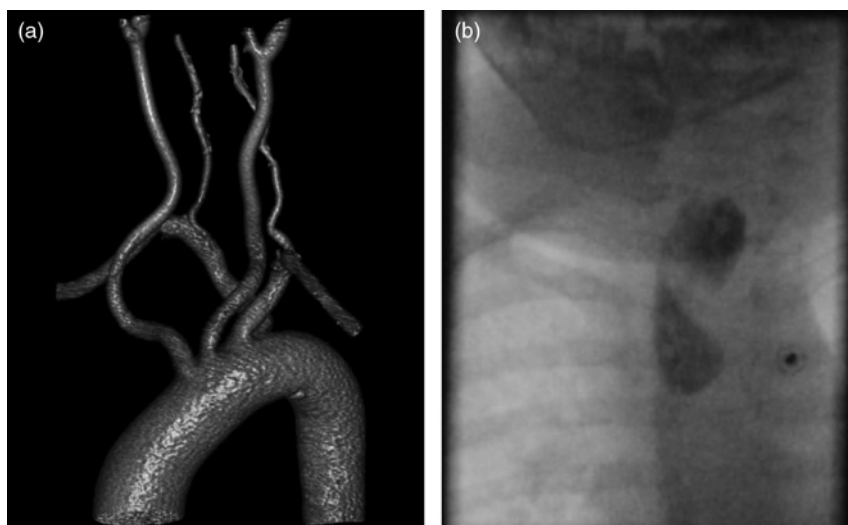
Contrast material assisted multidetector CT (a) of an arteria lusoria in a 59-year-old man. X-ray examination (b) of the esophagus of a female infant with an arteria lusoria and dysphagia
